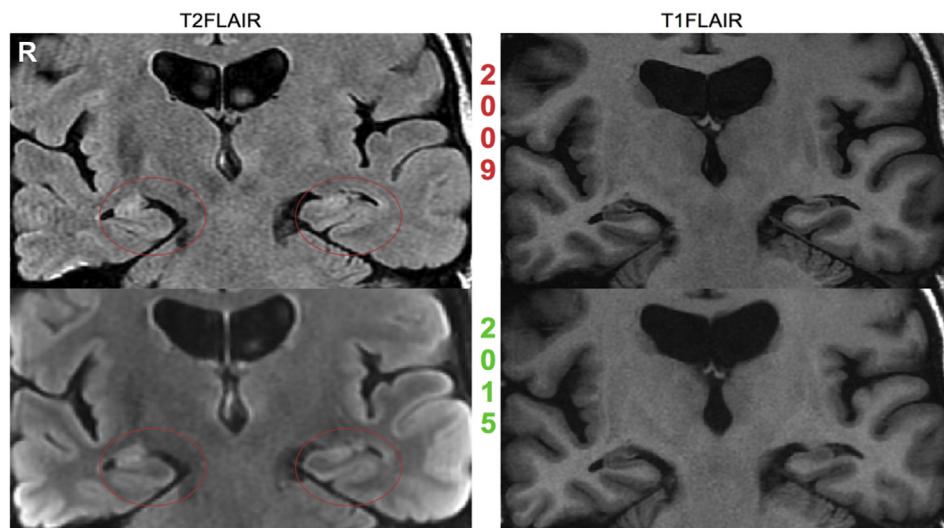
Patient 25: bilateral HS. The images from 2009 show bilateral HS as demonstrated by hyperintensity on T2-FLAIR and volume loss on T1-FLAIR; this was referred to as “bilateral small hippocampi” by the expert neuroradiologist. This was inappropriately documented and the information did not reach the consultant neurologist. In 2015 the patient was diagnosed with bilateral HS. R = right.
